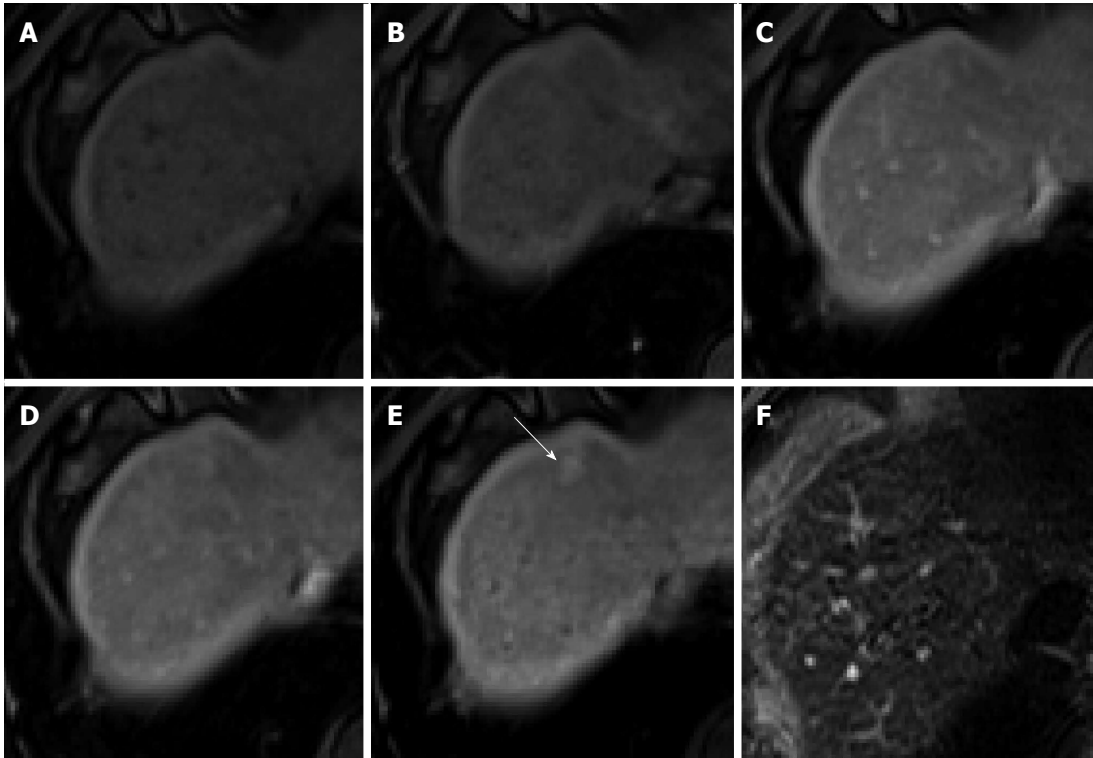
Regenerative nodule in a 61-year-old man with alcoholic liver cirrhosis. A-D: Precontrast T1-weighted image, hepatic arterial phase, portal venous phase, and transitional phase show no visible lesion in the scanned area; E: Hepatobiliary phase shows a hyperintense nodule (arrow) in hepatic S4; F: T2-weighted image shows isointensity of the tumor.
